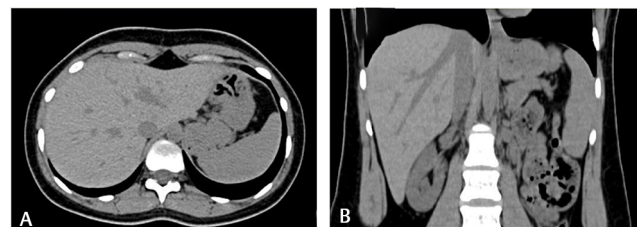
(A) Axial section of plain computed tomography (CT) of abdomen showing complete resolution of the portal vein gas and pneumatosis within the stomach and duodenal wall. (B) Coronal section of plain CT of abdomen showing the complete resolution of the portal vein gas and pneumatosis within the stomach and duodenal wall.
